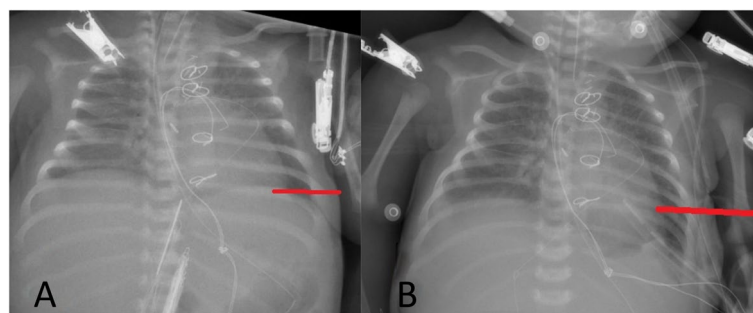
A Pre-plication chest radiograph of a patient operated for transposition of the great artery. B Post-plication chest radiograph of a patient operated for transposition of the great artery
